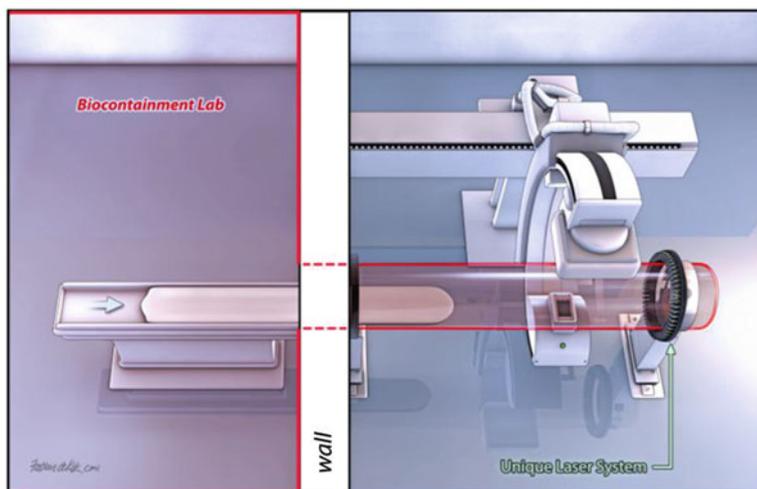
X-ray gantry with its containment tube and unique laser system (black collar around containment tube) to prevent the movable X-ray head from striking the tube as its position is adjusted. If the X-ray head interrupts any laser beam, the power is immediately shut off. The barrier wall and containment tube separate the equipment from the laboratory. All rights reserved. Reprinted with permission from the American Biological Safety Association (ABSA), Mundelein, IL. Originally published in *Applied Biosafety: Journal of the American Biological Safety Association*, 16(2), p. 60. Copyright © 2011. Visit <http://www.absa.org> for more information
